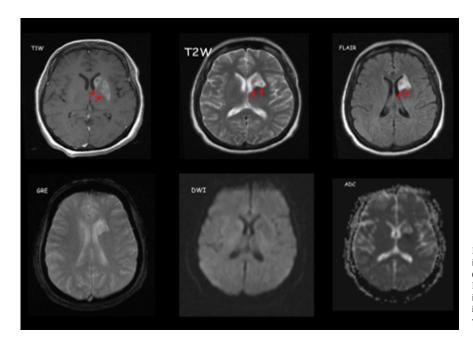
MRI: T1W, T2W and FLAIR images revealed hyperintense signals (red arrows) in the left internal capsule. Diffusion-weighted imaging and ADC imaging showed no evidence of acute ischaemia. Gradient echo imaging revealed no susceptibility artefact.
